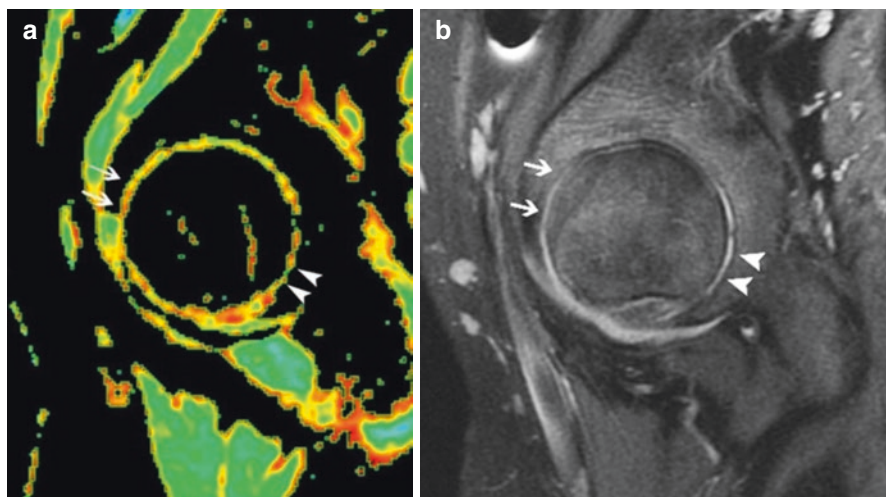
14-year-old FAI patient. (a) Sagittal cut of the T2 mapping MR image indicates loss of cartilage tissue which represented by red and orange colors. Anterior (arrow) and posteroinferior (arrowheads) localization of the defect is highly considered to be pincer-type impingement due to protrusio acetabuli. (b) Sagittal fat-saturated MR image of the same patient. Arrows and arrowheads mark the thinned articular cartilage layer. (Reprinted by the permission of Springer-Verlag, Radiologic analysis of femoral acetabular impingement: from radiography to MRI, Dwek, J.R., Monazzam, S. & Chung, C.B. *Pediatr Radiol* (2013) 43(Suppl 1): 61. <https://doi.org/10.1007/s00247-012-2588-7>)
